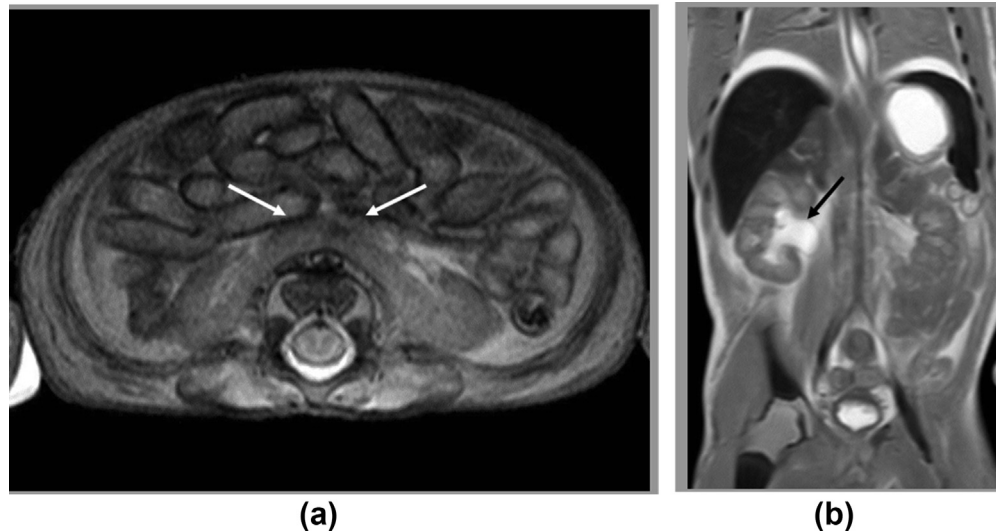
Two examples of misinterpretation in the initial PMMRI report, overruled at reassessment. (a) Axial T2-weighted image of a patient with a horseshoe kidney (white arrows), initially missed. (b) Coronal T2-weighted image of a patient with hydronephrosis of the right kidney (black arrow) not mentioned in the initial report.
